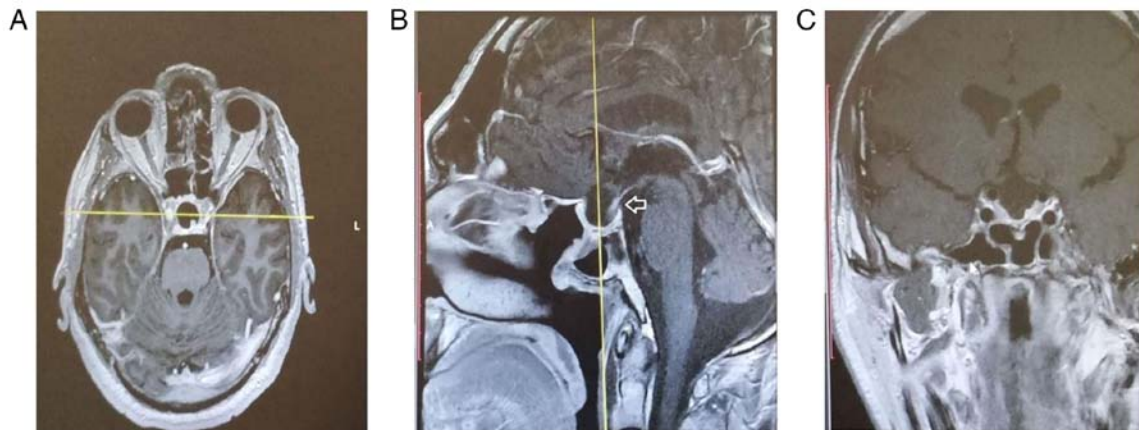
(A-C) Post-operative contrast enhanced T1 MRI scan of patient 2. No tumor is depicted, while the pituitary stalk is decompressed (arrow).
